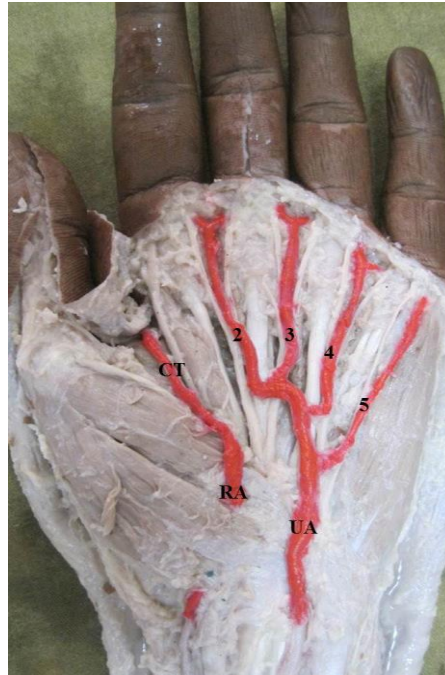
Left hand showing an Incomplete SVA(ulnar type, with ulnar artery supplying the medial three and a half digits and rest by the superficial branch of radial artery).UA – Superficial branch of ulnar artery; RA – Superficial branch of radial artery; 2, 3, 4 – 2nd, 3rd and 4th common digital arteries; 5 – Proper digital artery; CT – common trunk for arteria princepspollicis and arteria radialisindicis.
